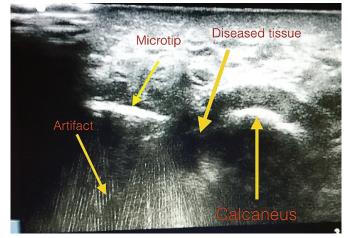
Microtip within the diseased ligament. Notice the artifact produced as the micro tip moves at ultrasonic speed through the diseased ligament.
